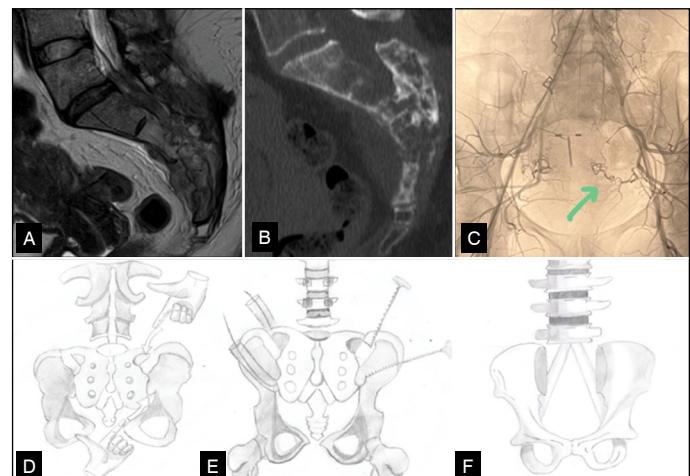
38-years old female with low back pain and sphincter dysfunction was diagnosed epithelioid hemangioendothelioma. A - CT in sagittal plane revealing multiple expansile lytic lesions. B - MRI showing tumor expansion into the epidural space. C – Arteriography study of the sacral tumor. D - Blunt digital dissection is performed proximally and distally using the index fingers to create an anterior plane separating the vascular structures and the lumbosacral trunk. E - A silicone tube is introduced, followed by the passage of a wire saw through the tube. The Gigli saw handles are then attached, and the osteotomy is performed in a posterolateral direction. F - For the Cathedral reconstruction, docking sites are created centrally in the lowest remaining vertebral body and bilaterally in the iliac wings.
